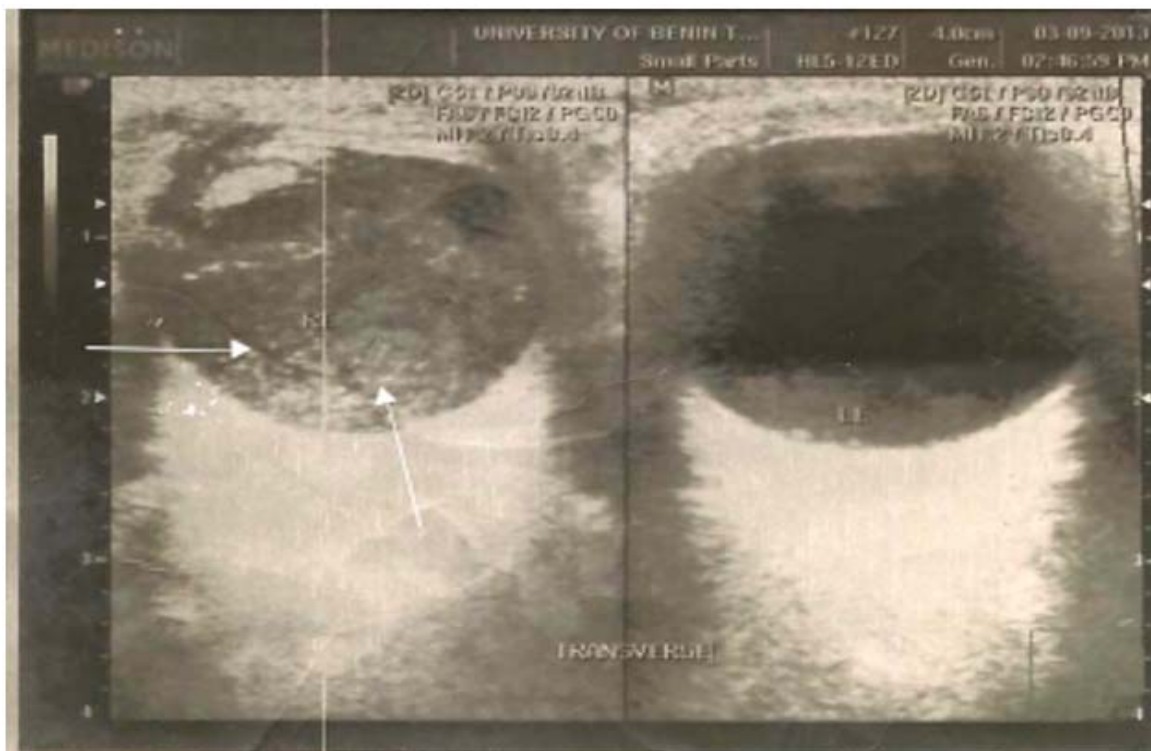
Ultrasound image showing bright echoes in the posterior chamber (arrow), due to vitreous haemorrhage.
